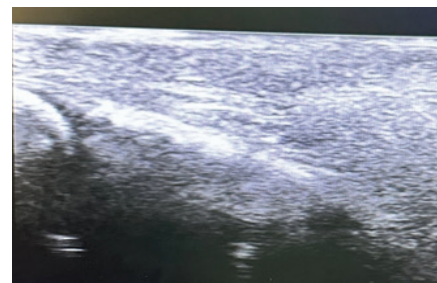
Sonogram of the intervertebral region one year after surgery
